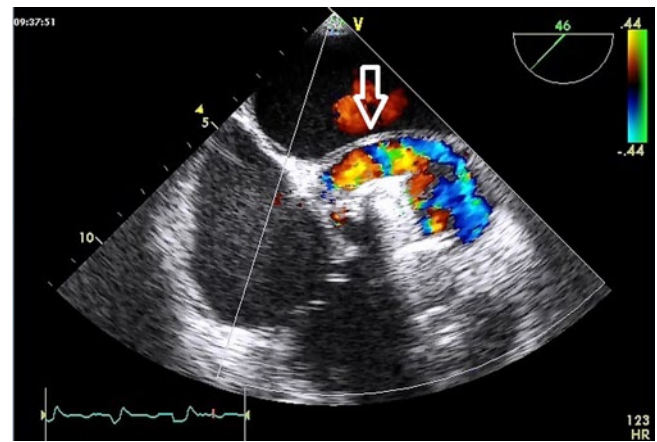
▲ Color Doppler view of a pseudoaneurysm (arrow)
